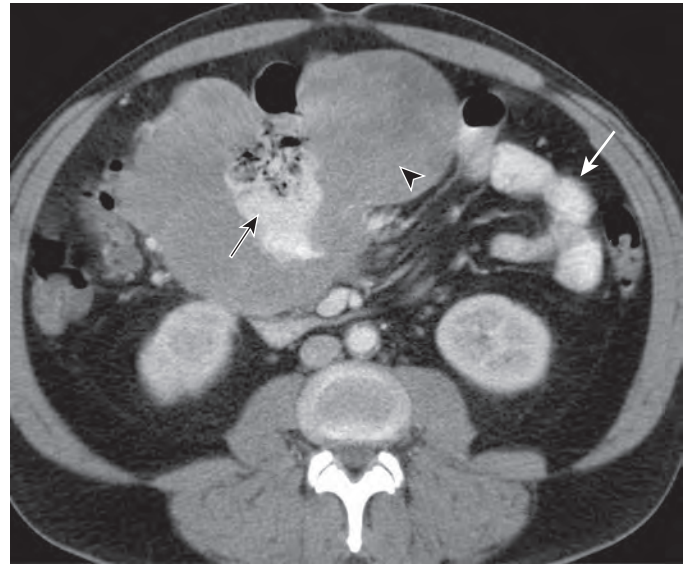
Aneurysmal bowel dilation in lymphoma. This 48-year-old man presented with abdominal pain and anemia. Axial CT shows a 12-cm small bowel mass (arrowhead) with a distended lumen containing oral contrast and gas (black arrow), a finding known as *aneurysmal bowel dilation*. The proximal bowel (white arrow) was unobstructed. This patient had B-cell non-Hodgkin lymphoma.
